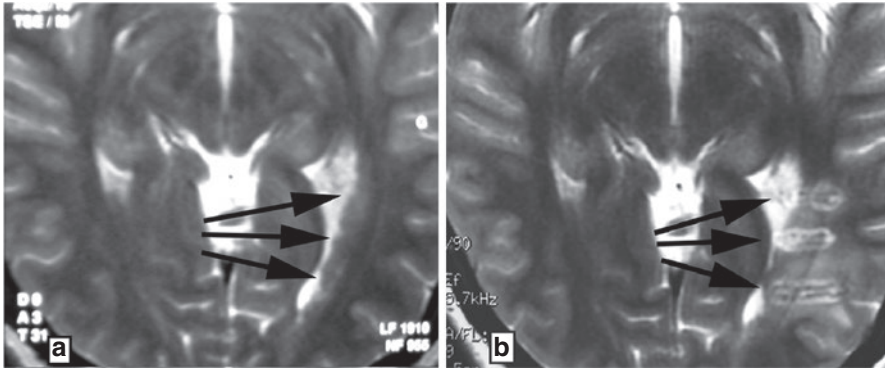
MRI scans displaying a left posterior periventricular heterotopia (arrow) before (a) and after (b) SEEG-guided RF-TC
